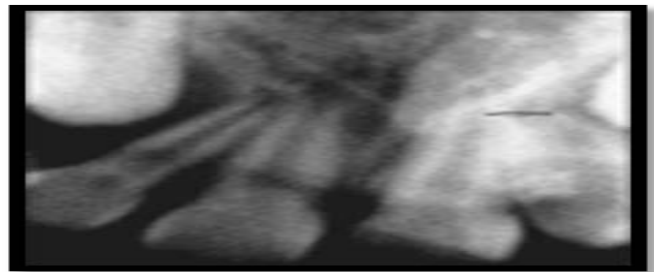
Periapical radiograph showing wide open apex
